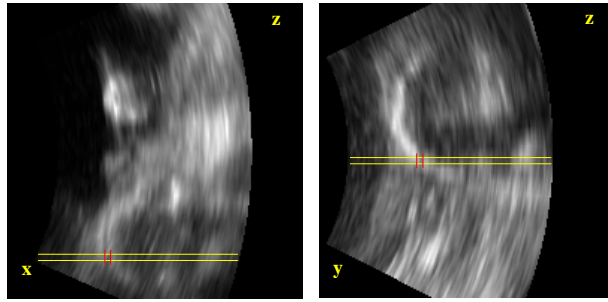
Two orthogonal cross sections of the ultrasound data set of Figure 8. The position of the intensity profile of Figure 2 is between the yellow lines. The position of the interface between amniotic fluid and fetal head detected by analysis of a tube core is indicated by short red lines.
